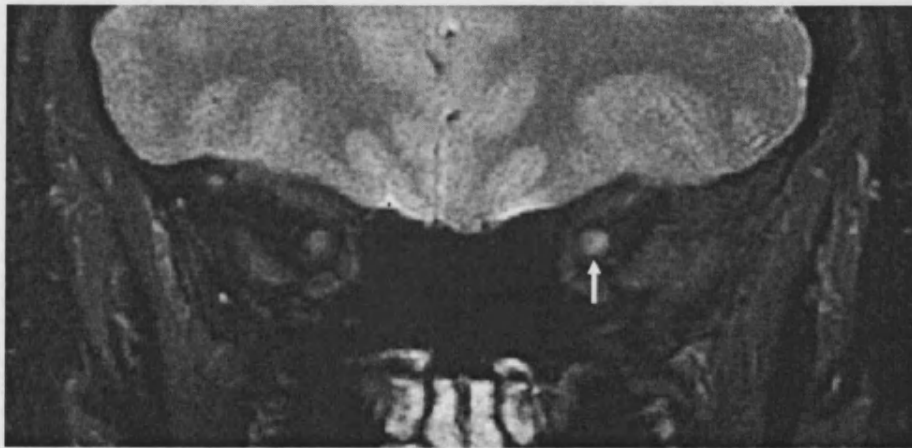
Fat-saturated proton density FSE MRI in left-sided acute optic neuritis (diseased optic nerve arrowed).
